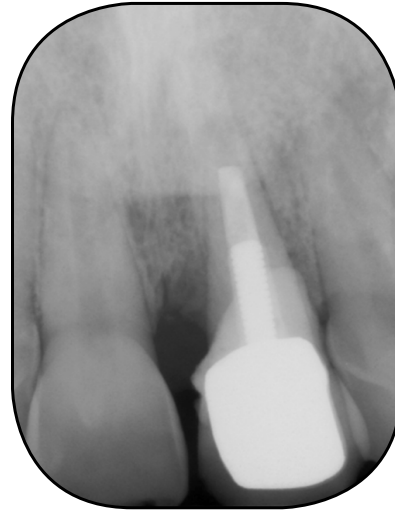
Periapical film showing failing tooth #21
